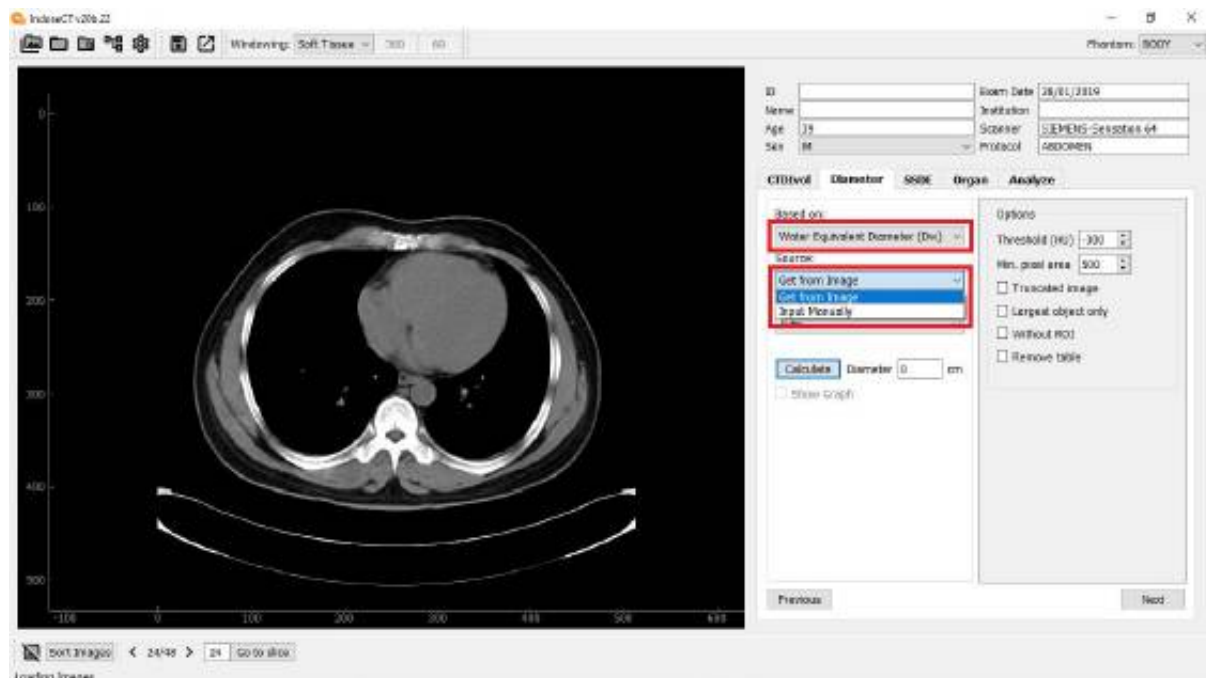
Calculation of D_w there are two choices of methods, namely: Manually and Get From Image. To use the Get From Image option, the user must have opened the patient's CT image in DICOM format.
